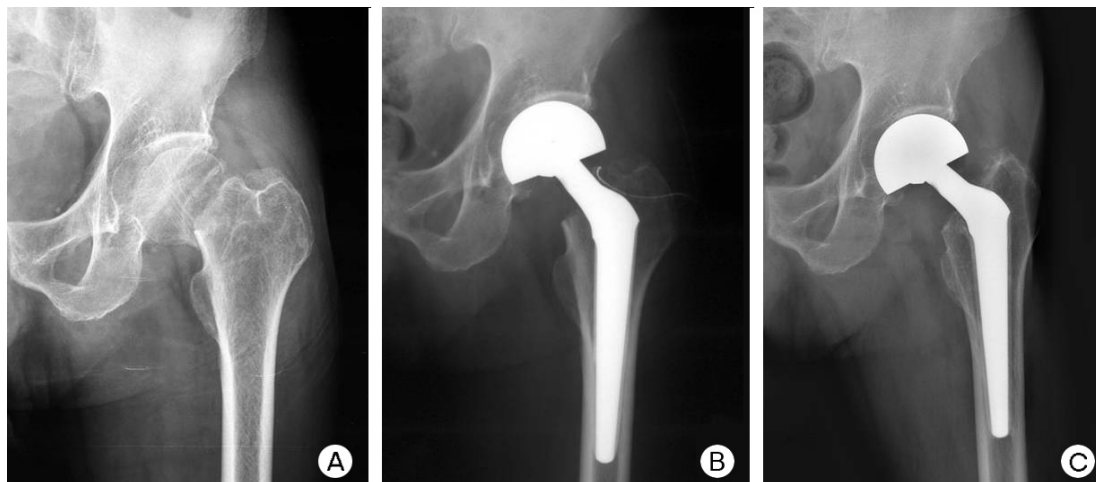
(A) Preoperative radiograph of 80 year-old male with left displaced femoral neck fracture. (B) Postoperative radiograph of same patient after undergoing uncemented bipolar hemiarthroplasty via posterolateral mini-incision. (C) Radiograph taken 65 months postoperatively showing good bony integration; the patient’s Harris hip score at this time was 85.
